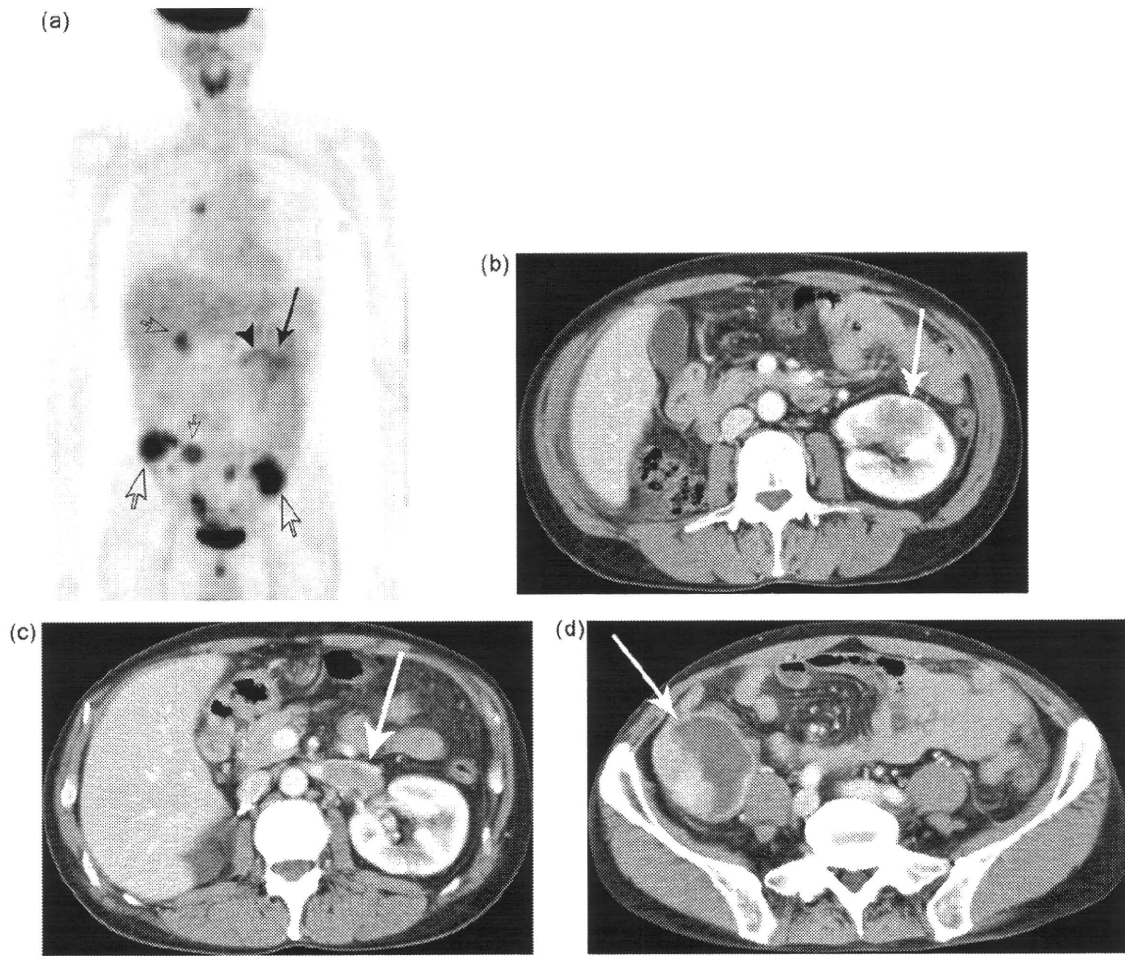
A case with metastatic renal cell carcinoma to the peritoneum, right hilar nodes, and left kidney. A maximum intensity projection image of FDG-PET (a) and axial slices of enhanced CT (b-d) are demonstrated. Metastatic lesions to the contralateral kidney (a: black arrow, b: white arrow) and to the peritoneum (a, d: white arrows) were identified as FDG-avid foci. Tumor thrombus in the left renal vein is also seen on PET and CT (a: arrowhead, c: white arrow).
